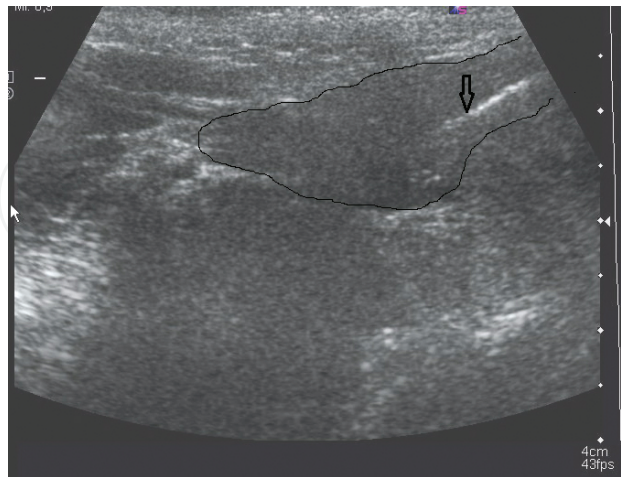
Ultrasonographic guidance during intraglandular injection of BoNT into the submandibular gland. The tip of the injection needle is indicated by an arrow. (GE Logiq 9, “thyroid” settings; 12 MHz linear transducer).
